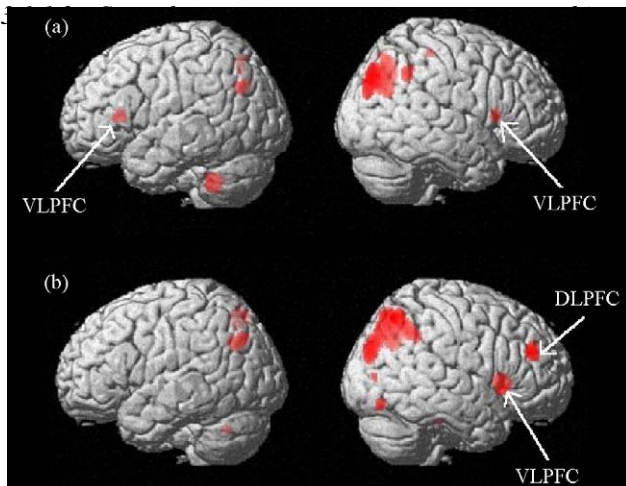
PET subtraction images rendered onto the surface of a standard MNI 3D MRI from SPM99: (a) non-structured array span task minus control task and (b) structured array span task minus control task. In each case, all activations above the small volume correction calculated just for the frontal lobes ($Z = 3.91$) are shown. Posterior activations appearing in the figure but not listed in Table 1 should be taken as non-significant, as these would not pass the whole brain corrected threshold. (DLPFC = dorsolateral prefrontal cortex; VLPFC = ventrolateral prefrontal cortex.)
